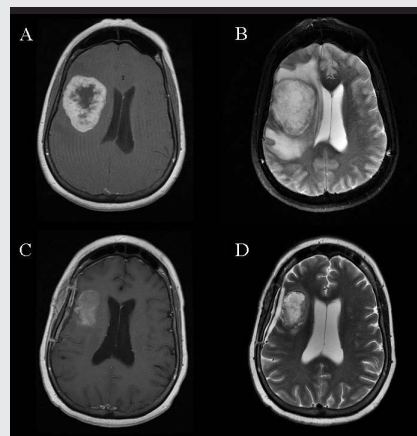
55-year-old female presenting with generalized tonic clonic seizure and one-month history of left-sided weakness and severe headaches. MRI of the brain, T1 weighted image with gadolinium contrast (A) and T2 weighted image (B) demonstrated a 5-cm heterogeneously enhancing mass (metastatic adenocarcinoma of the colon primary) with significant peritumoral edema and mass effect. MRI of brain two months after surgical resection and completion of whole brain radiation therapy (C and D) showed resolution of edema and mass effect with a small amount of blood product within the resection cavity.
